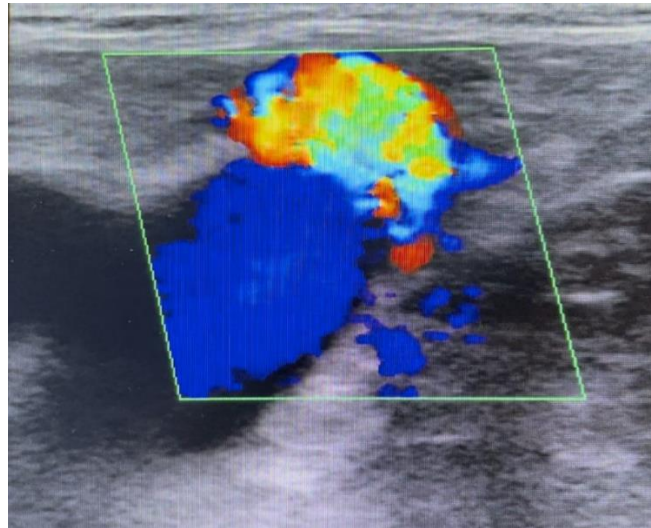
Pre-operative Duplex ultrasonography indicating the presence of reflux blood flow at the site of the saphenous varix when the patient was asked to cough
